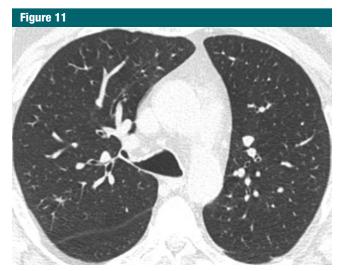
Bronchial wall thickening. CT scan in cigarette smoker demonstrates marked thickening of segmental and subsegmental airways but no emphysema.
